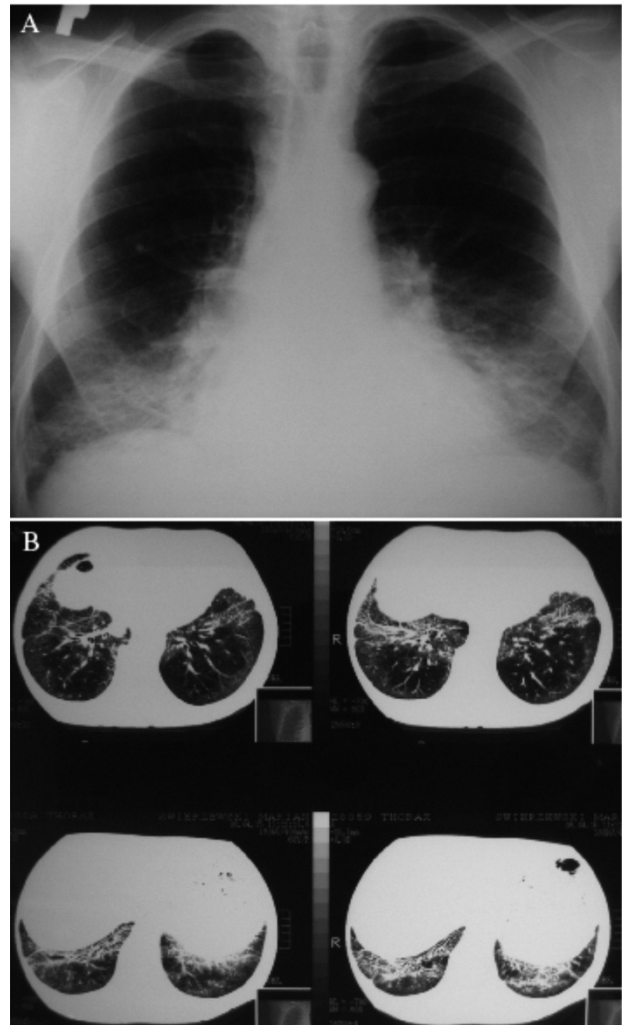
X-Ray (Panel A) and HRCT (Panel B) findings. Bilateral patchy consolidations and ground-glass opacities.
